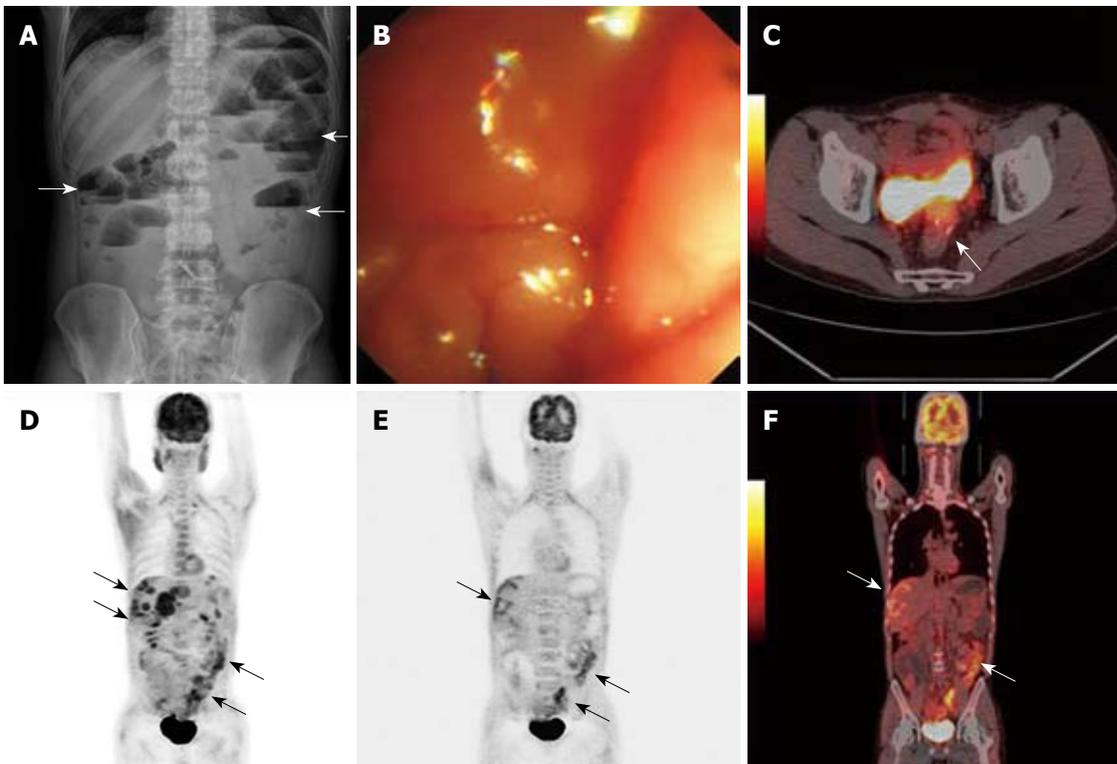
Extrapelvic metastases and perirectal recurrence. Plain abdominal radiograph, ES and PET/CT images obtained 30 mo after rectal cancer resection in a 41-year-old man. A, B: Plain abdominal radiograph and colonoscopy revealed the obstruction at the anastomotic site (arrows); C-F: PET/CT showed perirectal recurrence, peritoneal carcinomatosis and liver metastases (arrows).
